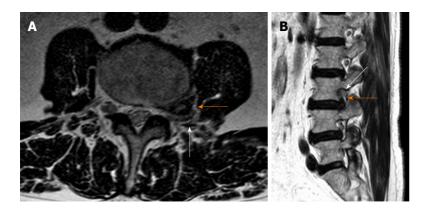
Axial (A) and sagittal (B) T2 magnetic resonance imaging showing a left L3-L4 extraforaminal far lateral lumbar disc herniations (orange arrow). The L3 root is severely compressed against the posterior border of the neural foramen (white arrow).
